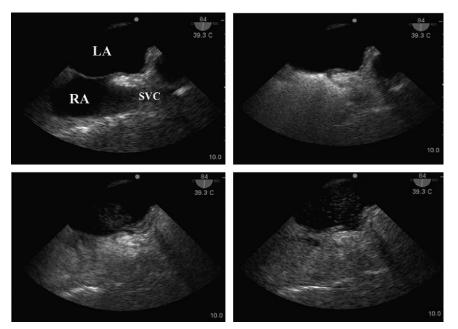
A 67-yr-old male patient had moderate to severe hypoxemia 2 days after a cardiac surgery. He was still on mechanical ventilation, with a high level of positive end-expiratory pressure. The chest radiograph did not show significant abnormalities. The possibility of having some degree of right-to-left shunt via a patent foramen ovale was entertained, and a transesophageal microbubble contrast study was performed at the bedside. *Top left*, an adequate TEE imaging plane to view the left atrium (*LA*), right atrium (*RA*), interatrial septum (the membrane seen between the LA and RA), and distal part of the superior vena cava (*SVC*) was obtained before injection of the microbubbles. *Top right*, microbubbles have just been injected and are seen completely opacifying the SVC and RA. *Bottom left*, within 2–3 heartbeats, the microbubbles are seen passing from the RA to the LA via a slit-like opening in the superior aspect of the interatrial septum, thus confirming the presence of a right-to-left shunt via a patent foramen ovale. *Bottom right*, a few seconds later, more of the left atrium gets filled with the bubble contrast. In such patient, the finding of a right-to-left shunt via a patent foramen ovale is of great importance, and an attempt will be made to lower the positive end-expiratory pressure and intrathoracic pressure as much as possible to decrease the degree of right-to-left shunting and associated hypoxemia.
